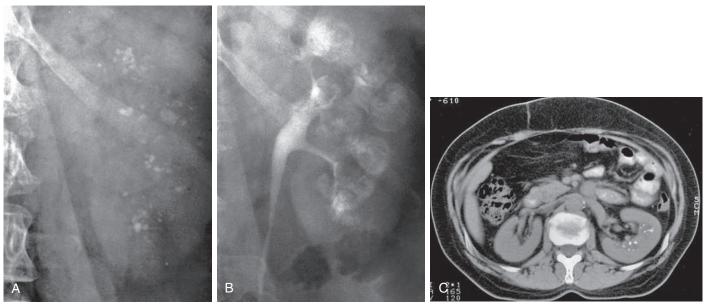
Radiologic findings associated with medullary sponge kidney. (A) Initial film shows medullary nephrolithiases. (B) Ten-minute film from excretory urography shows clusters of rounded densities in the papillae among discrete linear opacities (paintbrush appearance). (C) Nonenhanced CT reveals densely echogenic foci in the medulla.
